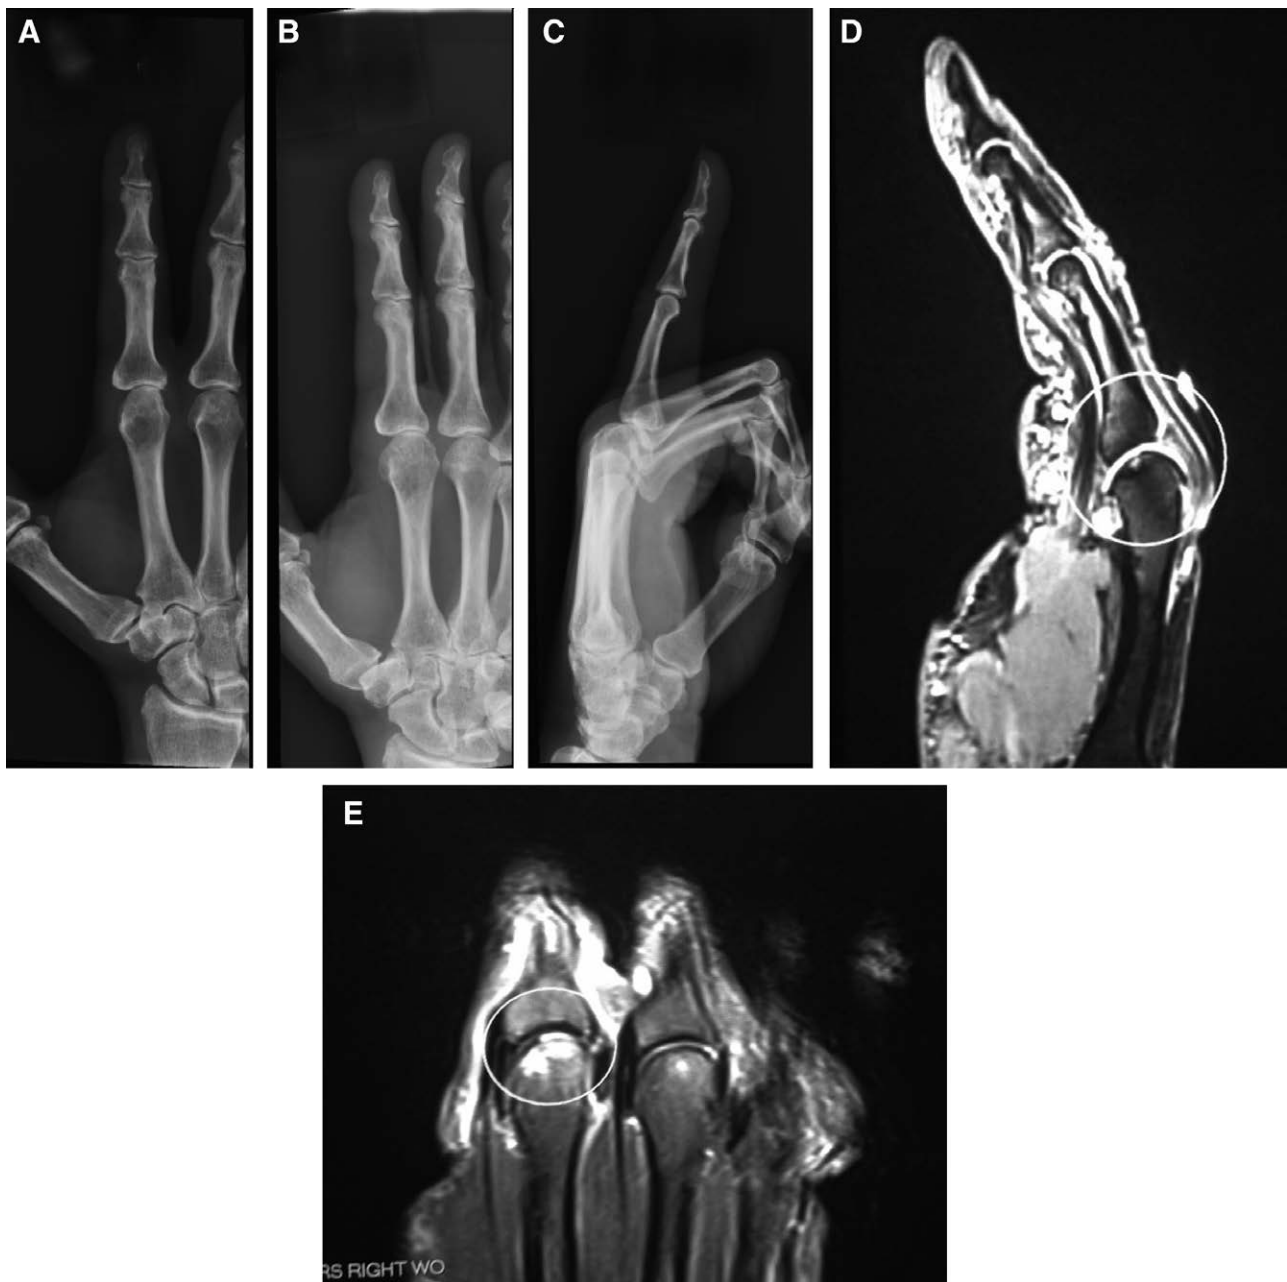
A–C, Postoperative x-rays of patient 10 revealing preserved joint space at 1 month. D, E, Postoperative MRI films showing meniscal transplant intact and in place at volar aspect of second MCP joint 3 months after surgery.
